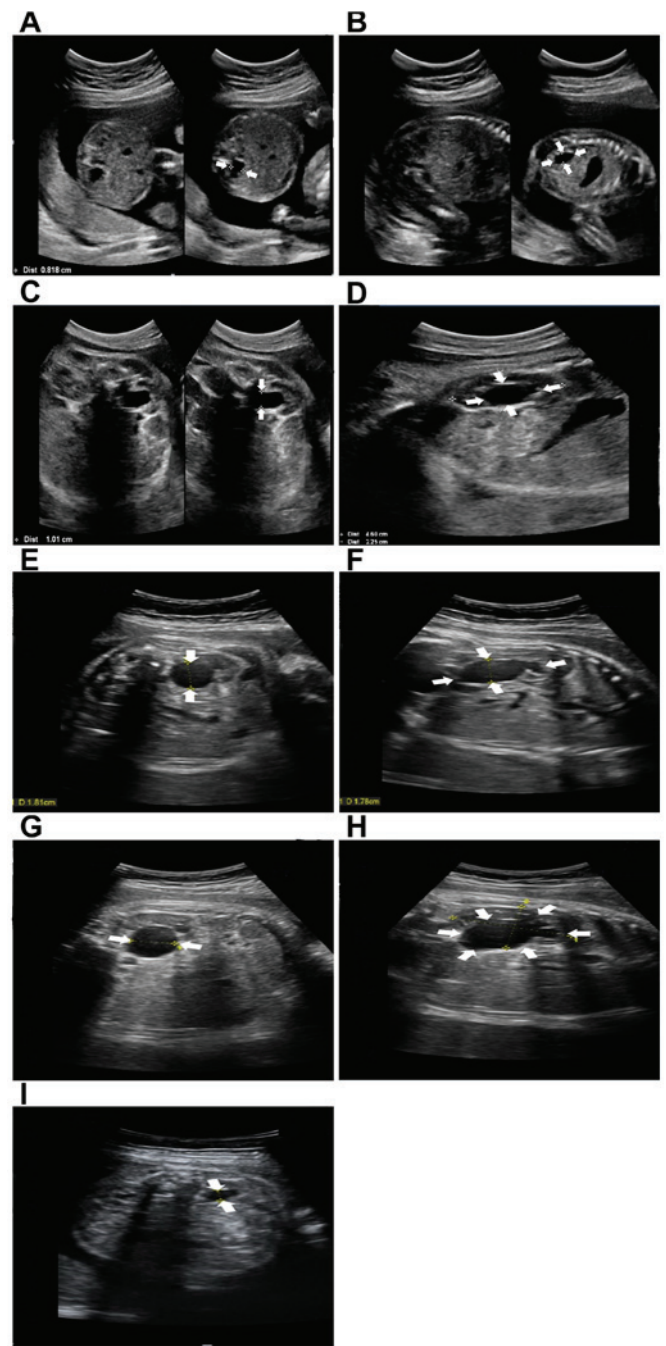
Ultrasound images of subjects with hydronephrosis with different SFU and APD grades. (A) Cross section of kidney with SFU grade I. (B) Vertical section of kidney with SFU grade I. (C) Cross section of kidney with SFU grade II. (D) Vertical section of kidney with SFU grade II. (E) Cross section of kidney with SFU grade III. (F) Vertical section of kidney with SFU grade III. (G) Cross section of kidney with SFU grade IV. (H) Vertical section of kidney with SFU grade IV. (I) Standard measuring section of APD. White arrows indicate the dilatation of the renal pelvis. SFU, Society for Fetal Urology; APD, anterior-posterior diameter.
